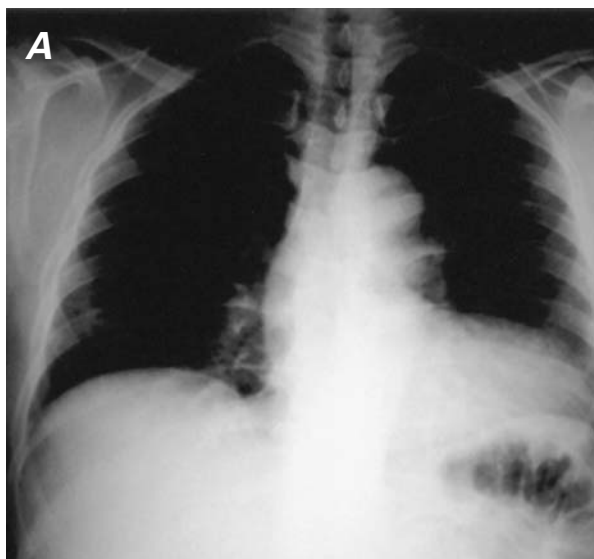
A) Chest radiograph shows mild enlargement of the mediastinal shadow and levoposition of the heart. B) Computed tomogram shows dissection of the descending aorta, shifting of the heart into the left hemithorax, and a severe left-sided hemothorax.
